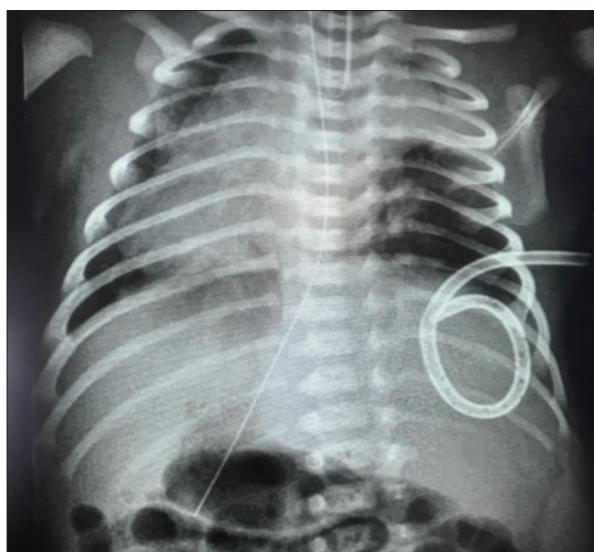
X-ray after left pneumothorax drainage.
